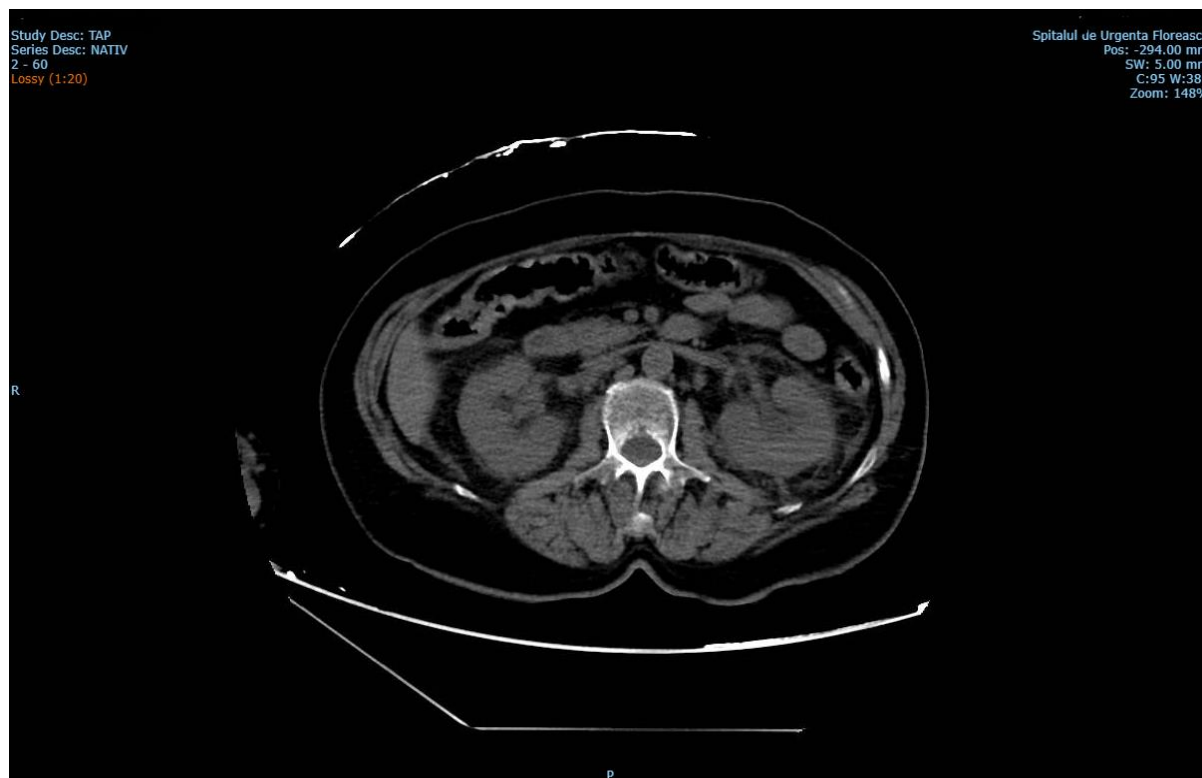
Nonenhanced computed tomography (CT) images showing a bilateral reduction in renal size.
